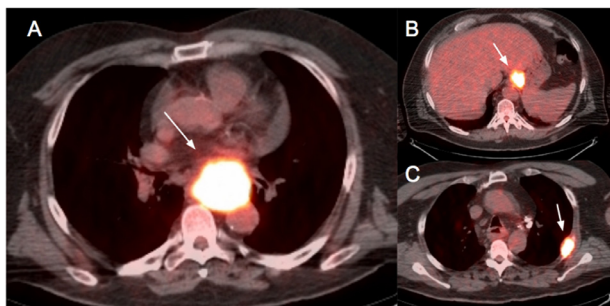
(a) Axial positron emission tomography (PET)/CT showing hypermetabolic thickening of the distal esophagus, characterized as the primary esophageal carcinoma. (b) Axial PET/CT showing hypermetabolic gastrohepatic lymphadenopathy, a metastatic lesion. (c) Axial PET/CT showing an fluorodeoxyglucose (FDG) avid metastatic left rib lesion.
